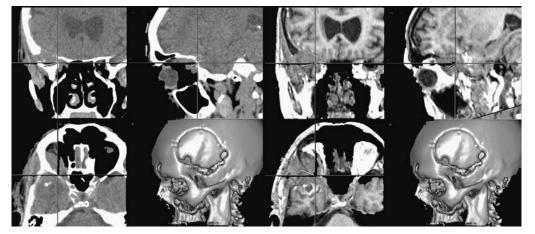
Image fusion between CT and MRI (here performed by "ImMerge"[™] StealthStation). The crosshairs show the same point localized on CT and MRI.
